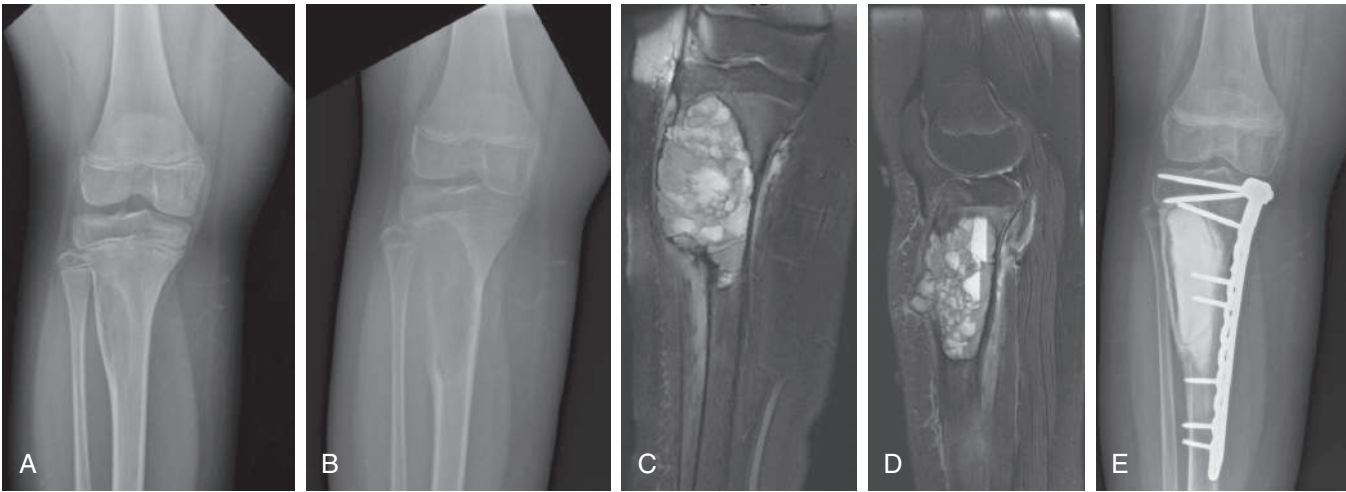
Aneurysmal bone cyst. A, A 10-yr-old female presents with right tibia pain after playing softball. PA radiograph of the right proximal tibia reveals an eccentric, lytic lesion. B, Repeat imaging 4 months later shows rapid expansion. C, Coronal T2 MR image. D, Sagittal T2 MR image shows fluid-fluid levels classically seen with aneurysmal bone cysts. E, The patient was treated with curettage, bone grafting, and plate fixation to prevent fracture.
